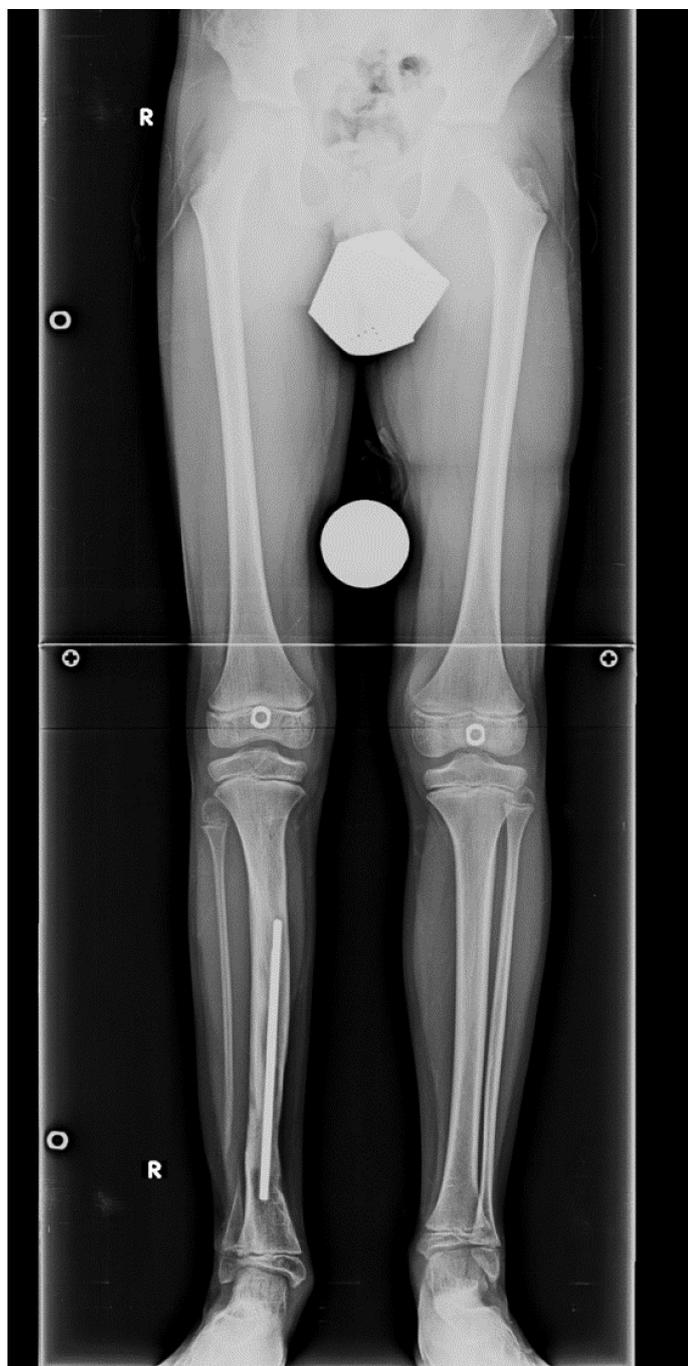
Solid union, good alignment, without residual ankle valgus, tibial bowing, and LLD were revealed by the long-standing lower extremity X-ray of the same patient at the three-year follow-up. The rod was maintained in the intramedullary cavity without affecting the ankle and subtalar joints
